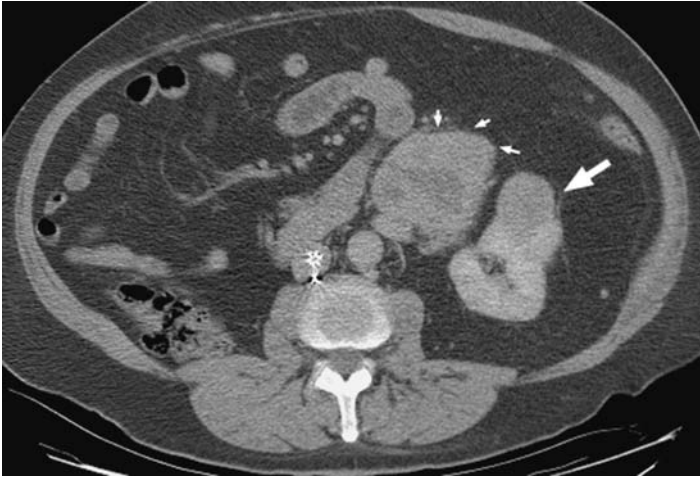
An enhanced axial CT scan showing a poorly enhancing mass arising from the lower pole of the left kidney representing a contralateral renal secondary tumor. The small arrows point to a large lymph node metastasis.
